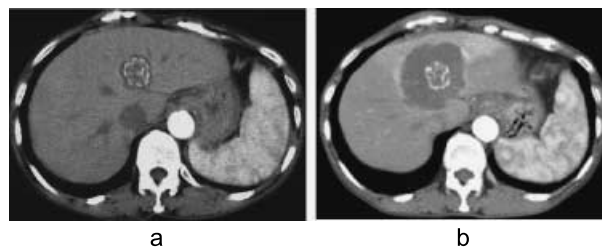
Contrast-enhanced CT ; (a) : July 2003, (b) : March 2004
